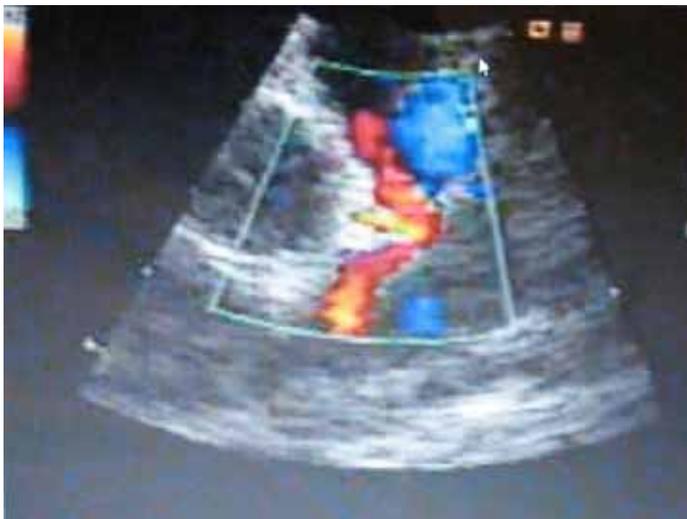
A trans-thoracic echocardiogram with apparent retrograde flow (in red) through the patient's left coronary.
